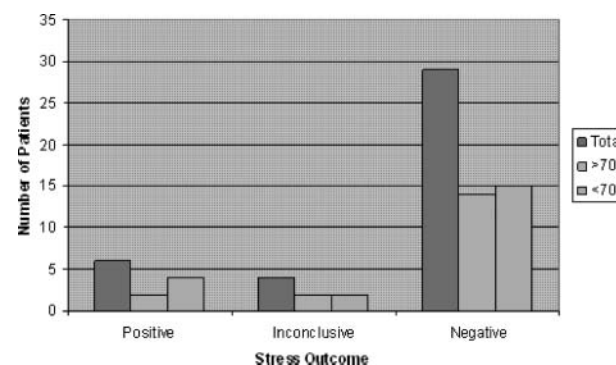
Outcome of stress Echocardiogram according to NICE risk scanning in the 61–90 class.
